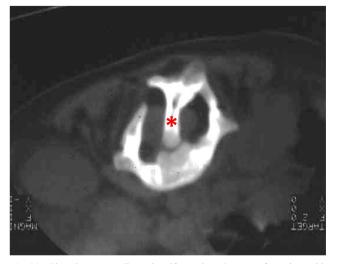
Closed NTD—split cord malformation. CT scan of a patient with a split cord malformation. The bony spur originates posteriorly (*asterisk*). Separate dural sheaths also enclose the two portions of the spinal cord
